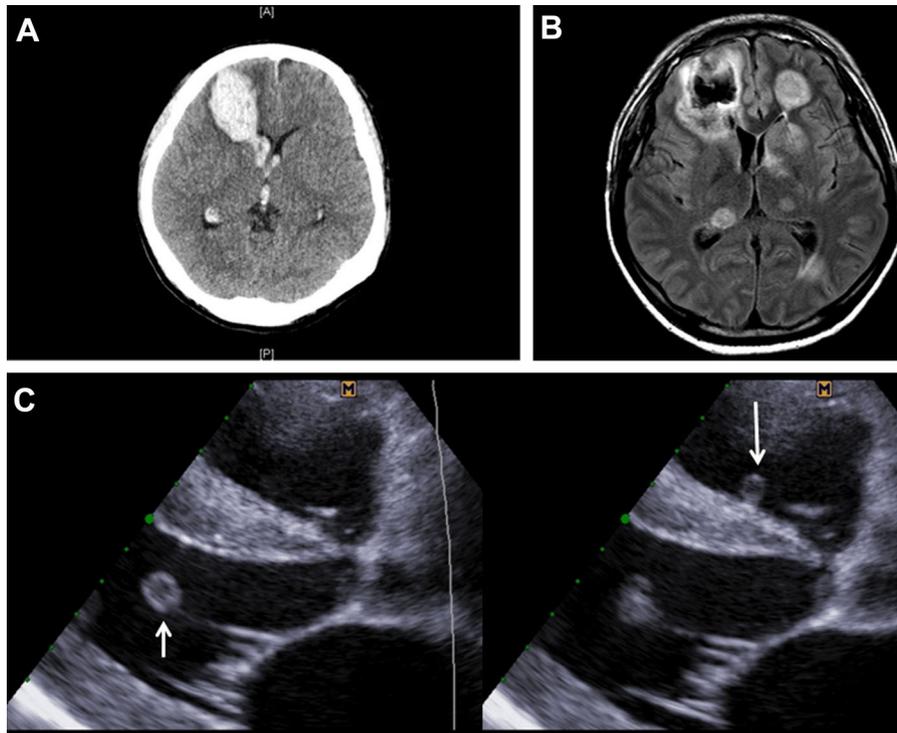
(A) Brain computed tomography of the heart transplant recipient on posttransplant day 7 showing acute intracerebral hemorrhage in the right frontal lobe. (B) Brain magnetic resonance image on posttransplant day 13 revealing multifocal embolic infarctions. (C) Echocardiography on posttransplant day 16 exhibiting 1 cm vegetation of the left ventricle (short arrow) and 0.5 cm vegetation of the right ventricle (long arrow).
